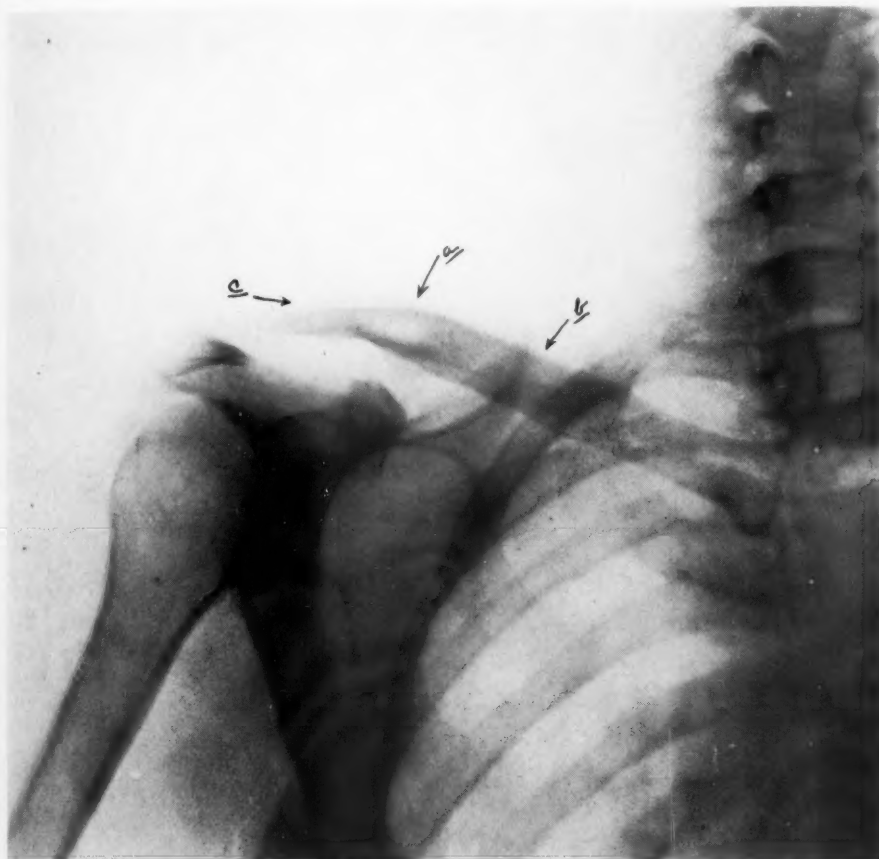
(CASE I.) Radiograph taken six months after institution of vigorous antiluetic treatment. The entire character of the process in the bone has changed and the normal contour of the clavicle is returning. At the point (a) there still remains a small vestige of the gummatous process seen in Fig. 1. At the point (b) periosteal thickening may now be detected, indicating the retrograde character of the disease in returning from the destructive to the proliferative phase. At the point marked (c) the bone has practically returned to its normal size.
